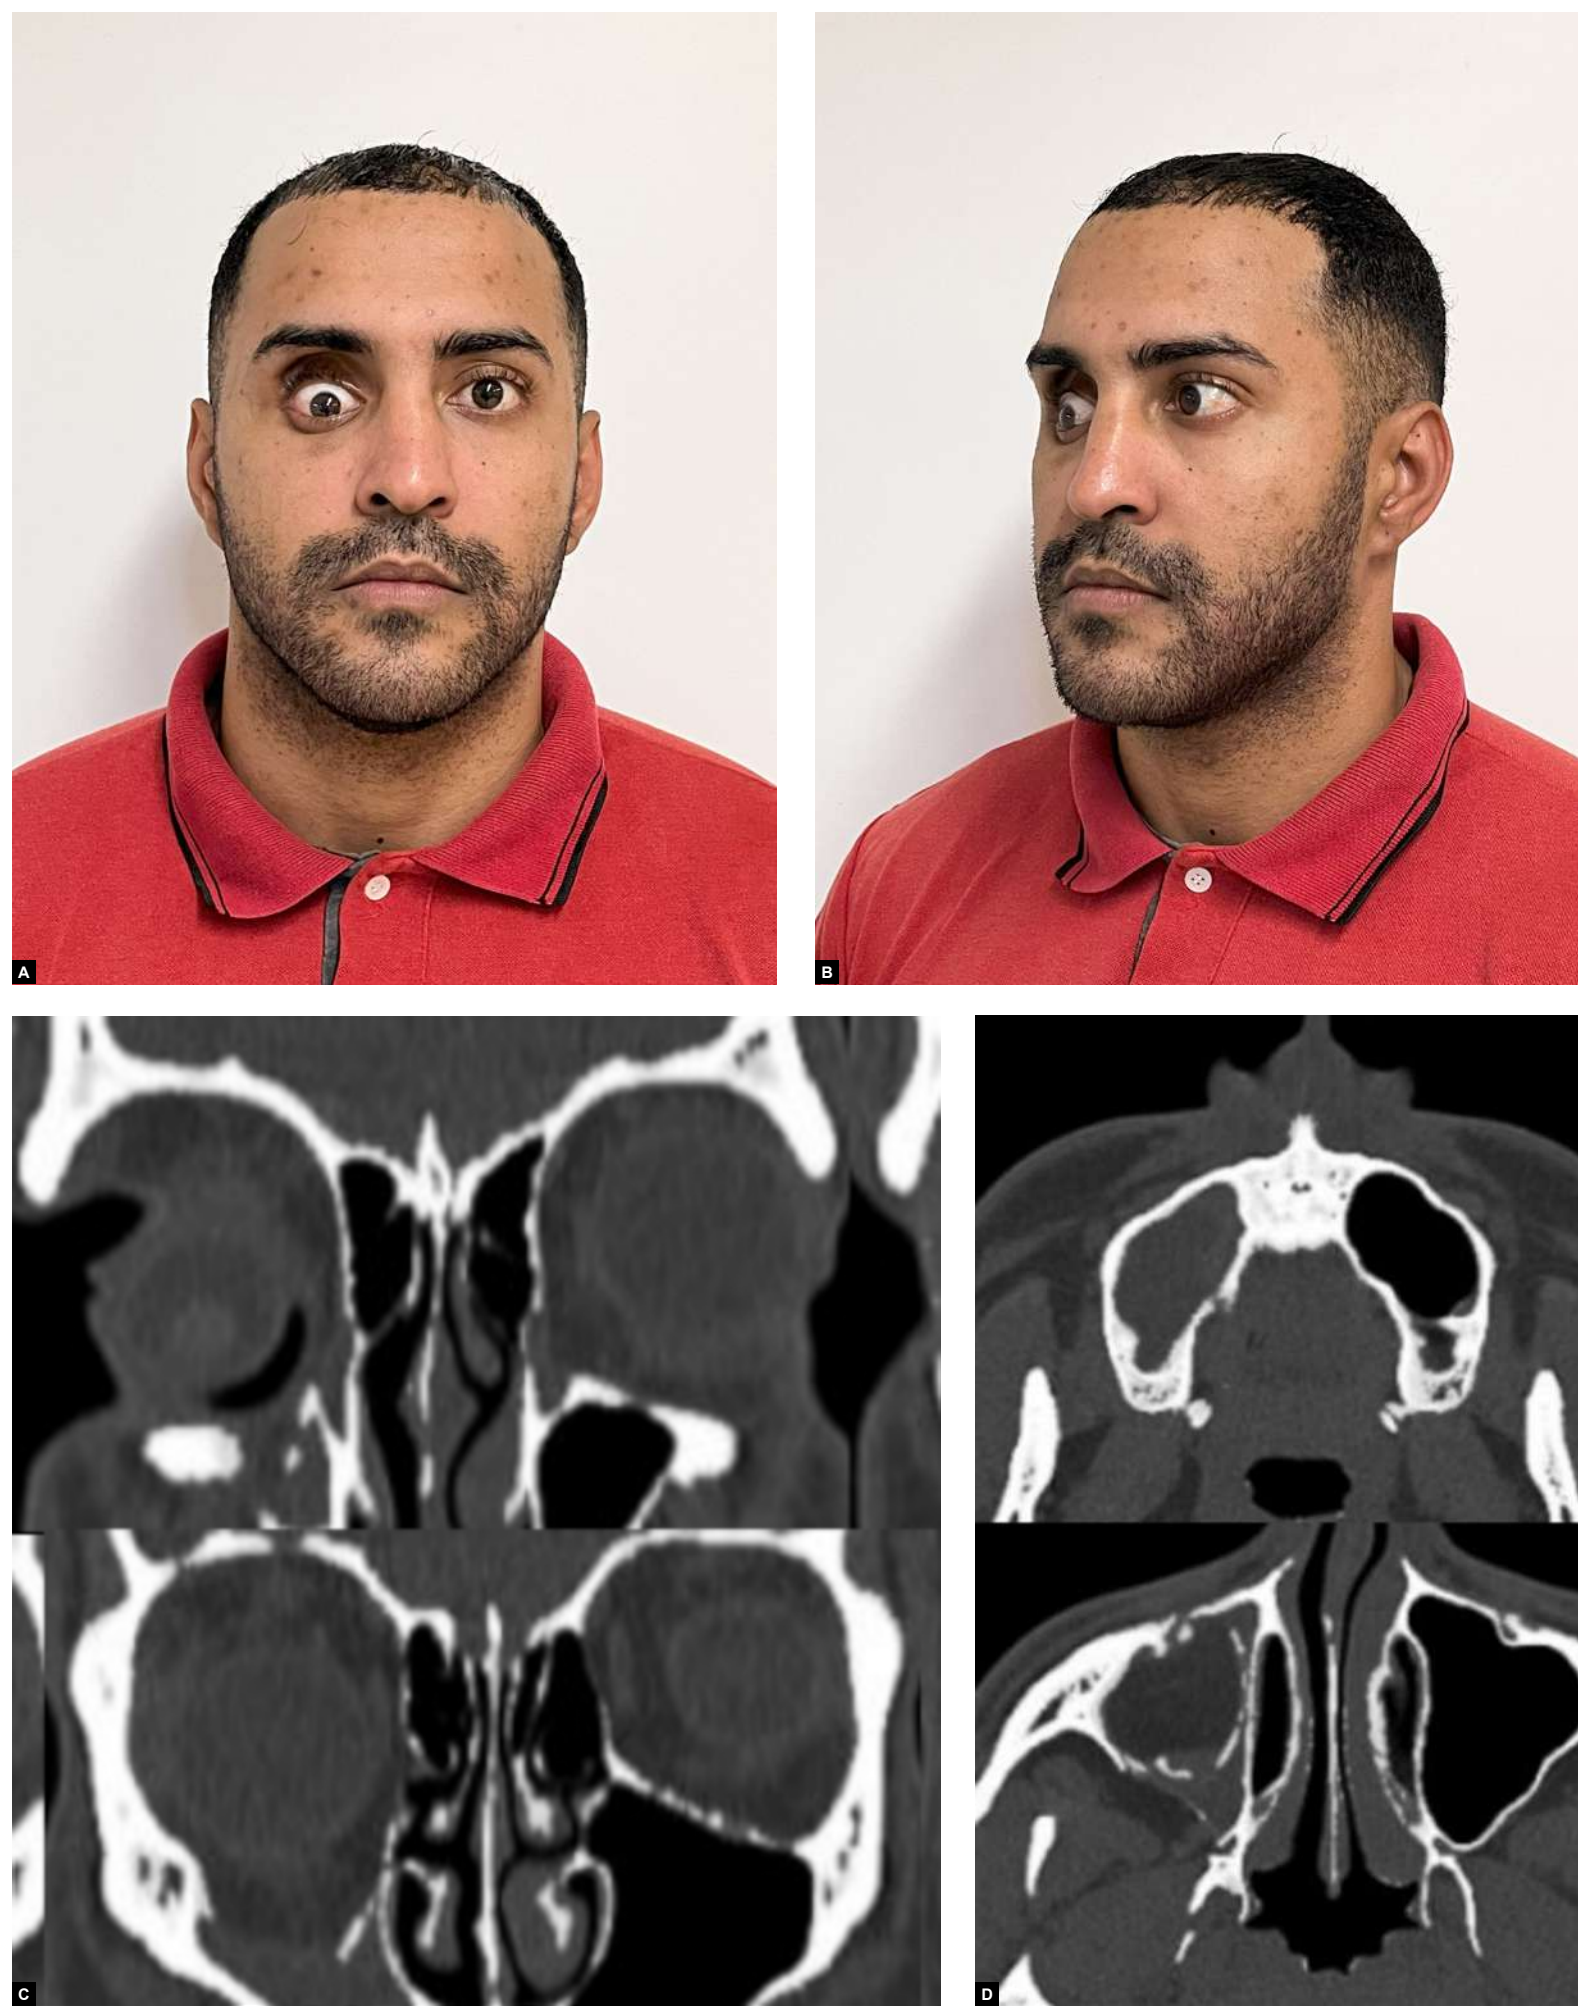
A) Frontal aspect. B) Oblique lateral view. C) Axial MSCT scans. D) Coronal CT scans.
